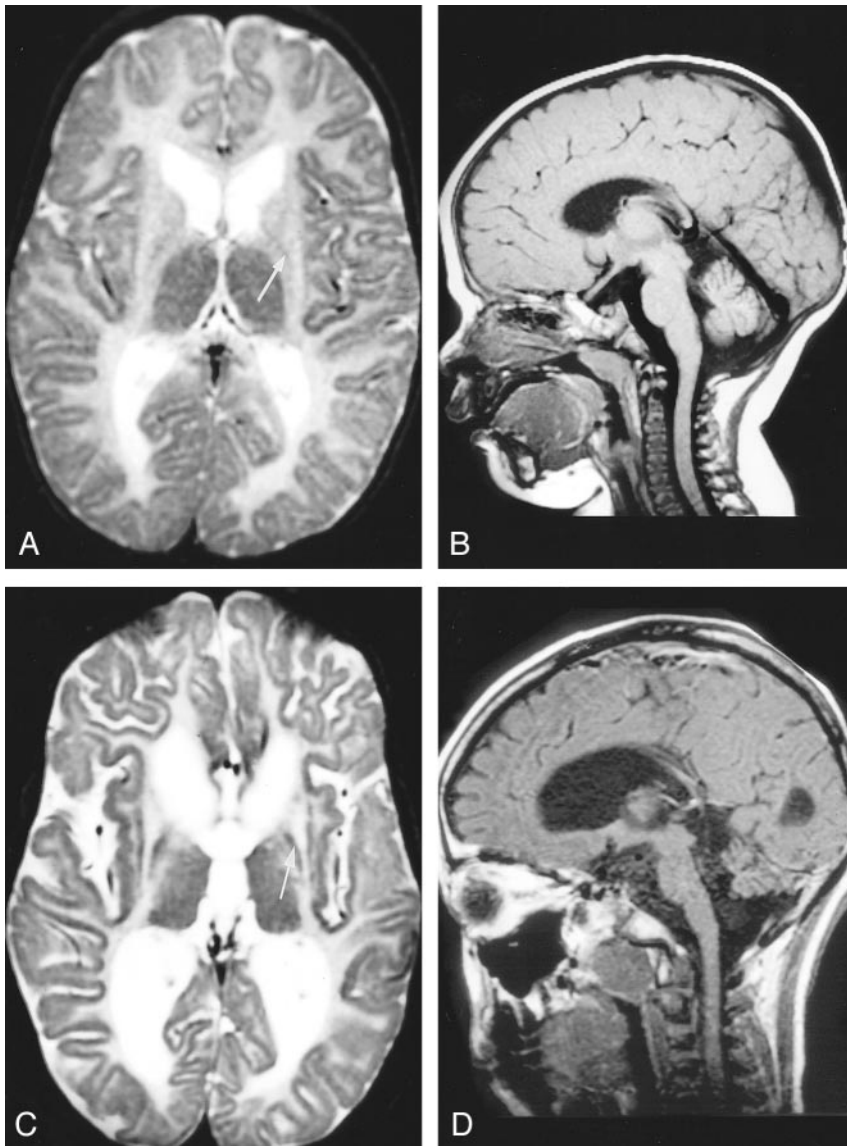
MR images in patient 5, who had severe clinical disease.
